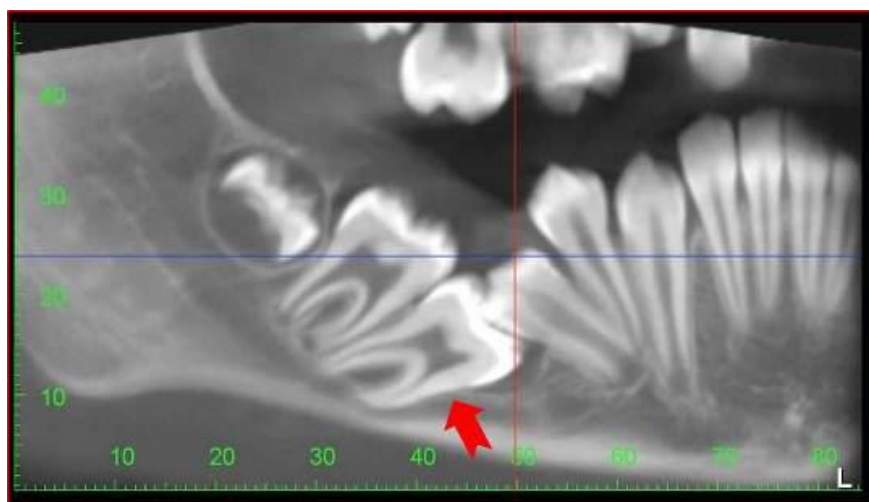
CBCT Scan showing mesial impaction of permanent mandibular right first molar (red arrow)
